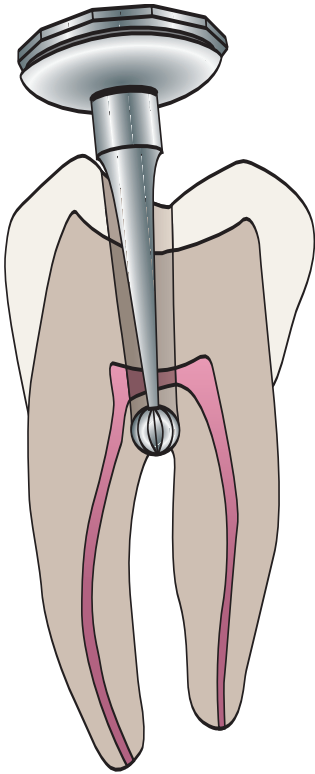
Operative errors—mandibular molars. Perforation into the furcation is caused by the use of too long a bur and a failure to recognize on the radiograph the depth of recession of the pulp. The bur should be measured against the radiograph and the depth marked on the shaft. This is a common error.
